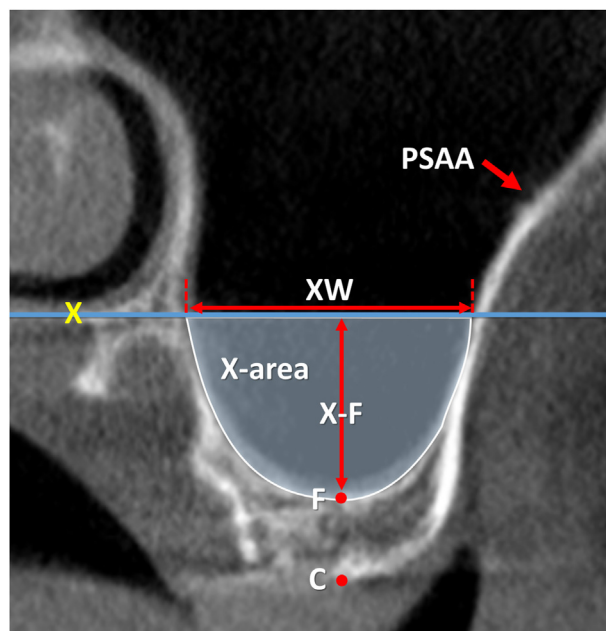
Coronal view of a CBCT before sinus floor augmentation. X, line drawn following the floor of the nose; C, center of the bony crest; F, base of the sinus floor; A, anastomosis. X-F, nasal floor height; XW (sinus width), i.e. the distance evaluated on the line X between the two intersection points with the medial and lateral sinus bone walls. X-area, area delimited by the sinus bone walls and the line X.
